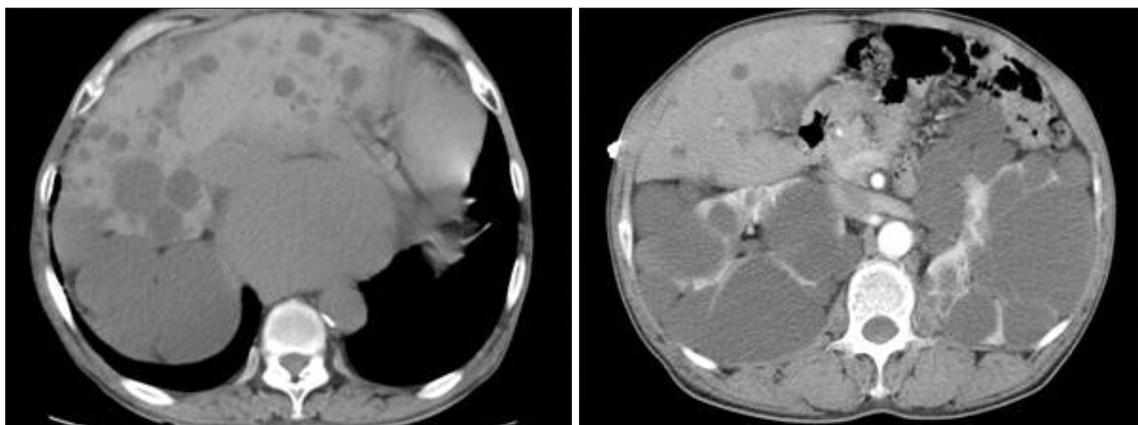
Abdominal computed tomography. Abdominal enhanced computed tomography shows multiple variable-sized cysts in both the kidney and liver. The abdominal aorta and branches are normal.
